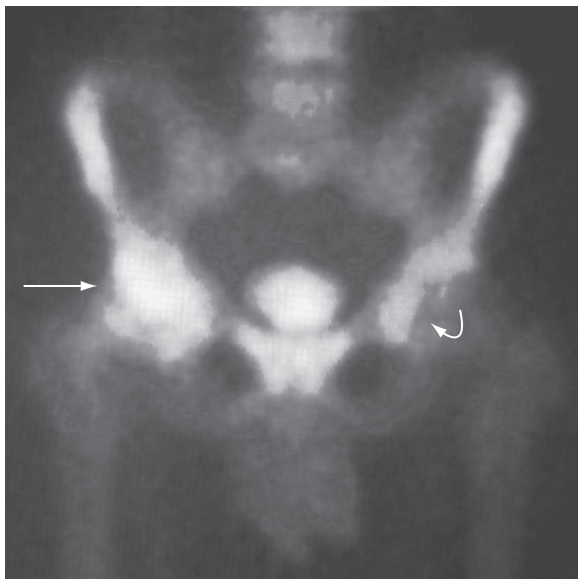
Bone scintigraphy of osteonecrosis of both femoral heads using Tc99m methylene diphosphonate showing moderate uptake of radiopharmaceutical at the site of the osteonecrotic segment in the right femoral head and markedly increased uptake at the site of bone repair (straight arrow). The left femoral head (curved arrow) exhibits early-stage disease.
